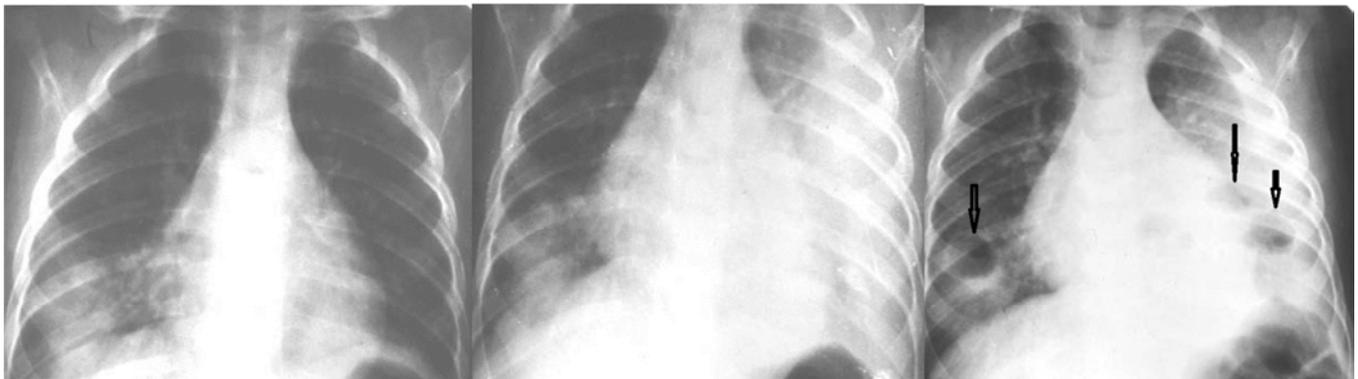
(X-rays of Case 1). A: Bilateral lower lobe infiltrates. B: Day 3 of treatment-massive pleural effusion with a vertical medial border. C: on day 10 air-filled cavities with some fluid within necrotic infiltrates bilaterally (arrows), receding layer of fibrin in the left pleural cavity.
